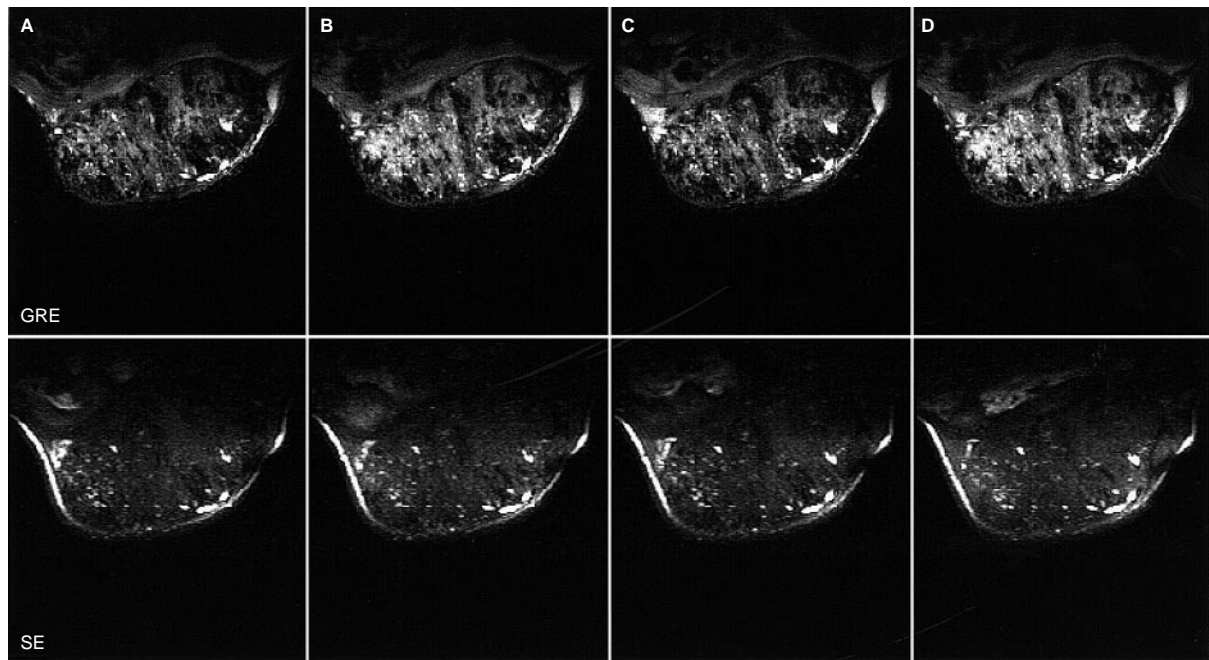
GRE and SE ^1H MR images of one GH3 prolactinoma acquired during (A) initial air breathing, (B) host carbogen breathing, (C) resumed air breathing and ca. 40 min post-administration of 1000 mg kg $^{-1}$ nicotinamide i.v. and (D) subsequent carbogen breathing and ca. 70 min post-nicotinamide
